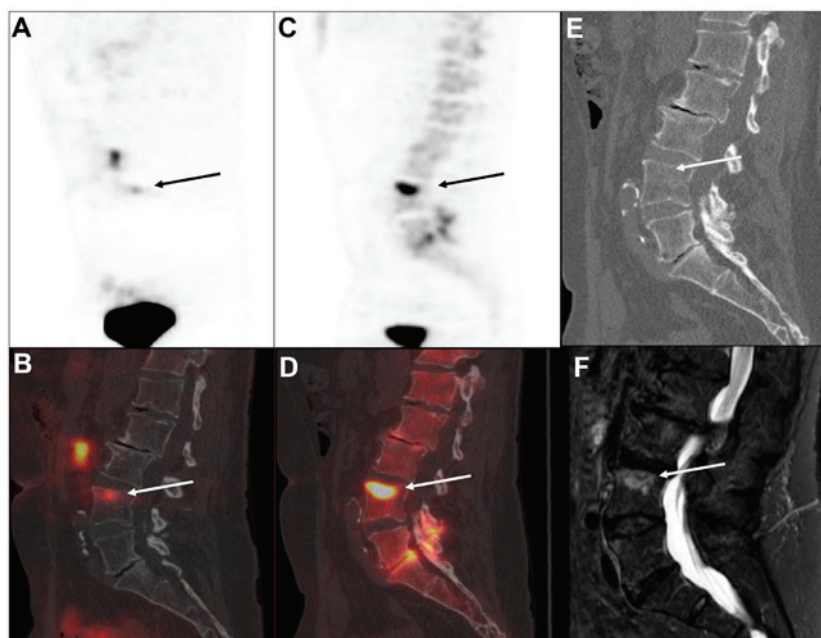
Imaging of bone metastasis in a patient with prostate cancer with biochemical recurrence. A single bone metastasis was identified in the upper part of the fourth lumbar vertebra indicated by the arrow in all the images. The lesion was identified by ^{68}Ga -PSMA-11 PET/CT as shown in (A) the sagittal view of the ^{68}Ga -PSMA-11 PET image with (B) the corresponding fused ^{68}Ga -PSMA-11 PET/CT and (C) by ^{18}F -NaF-PET with (D) corresponding fused images of NaF PET/CT. Morphological changes were recognized as (E) discrete sclerotic changes on the low-dose CT and (F) by magnetic resonance imaging exhibiting a high signal on the sagittal short TI-inversion recover image. PSMA, prostate specific membrane antigen; PET, positron emission tomography.
